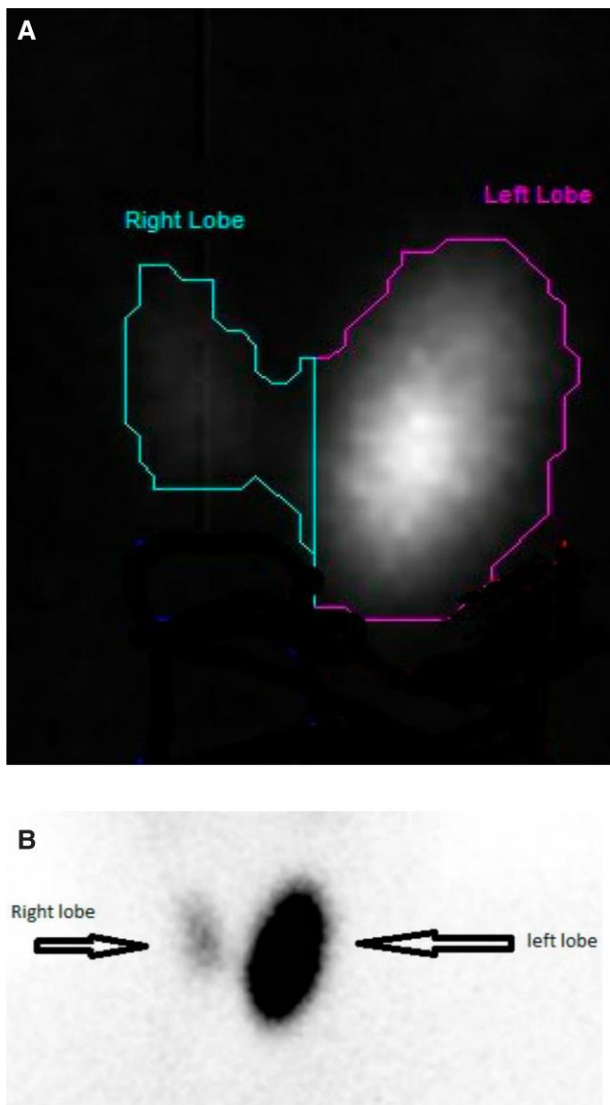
Nuclear medicine technetium-99M thyroid scintigraphy showing increased radiotracer uptake within the left thyroid lobe, whereas the right thyroid lobe shows suppressed uptake with no hot or cold nodules.
